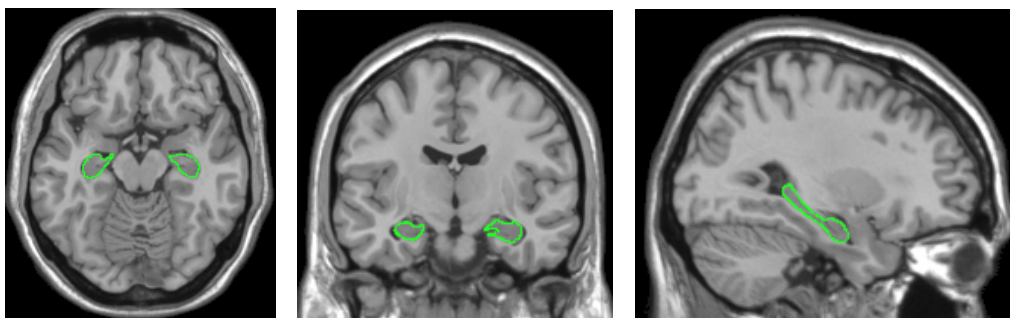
T1-weighted MRI showing boundaries for volumetric measures of hippocampus (in order, axial view $z = -15$, coronal view $y = -12$, and sagittal view $x = 30$).*
